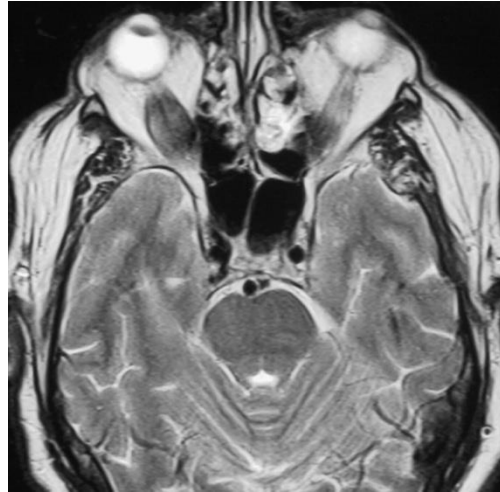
MRI axial section demonstrating enlarged inferior rectus muscles.
